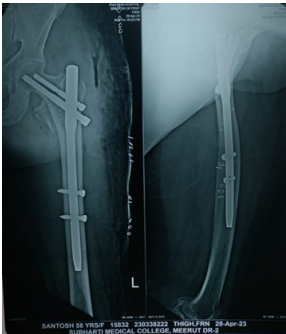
Figure -immediate Post- Op X-rays
